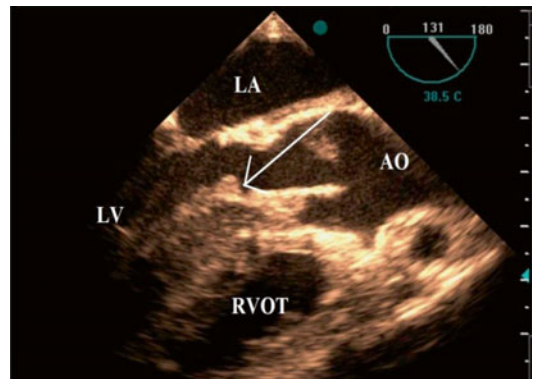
Parasternal long-axis view in transesophageal echocardiography showing fibromuscular ridge encircling the left ventricular (LV) outflow tract (white arrow) with extension to the anterior MV leaflet. LA left atrium, AO aorta, RVOT right ventricular outflow tract
